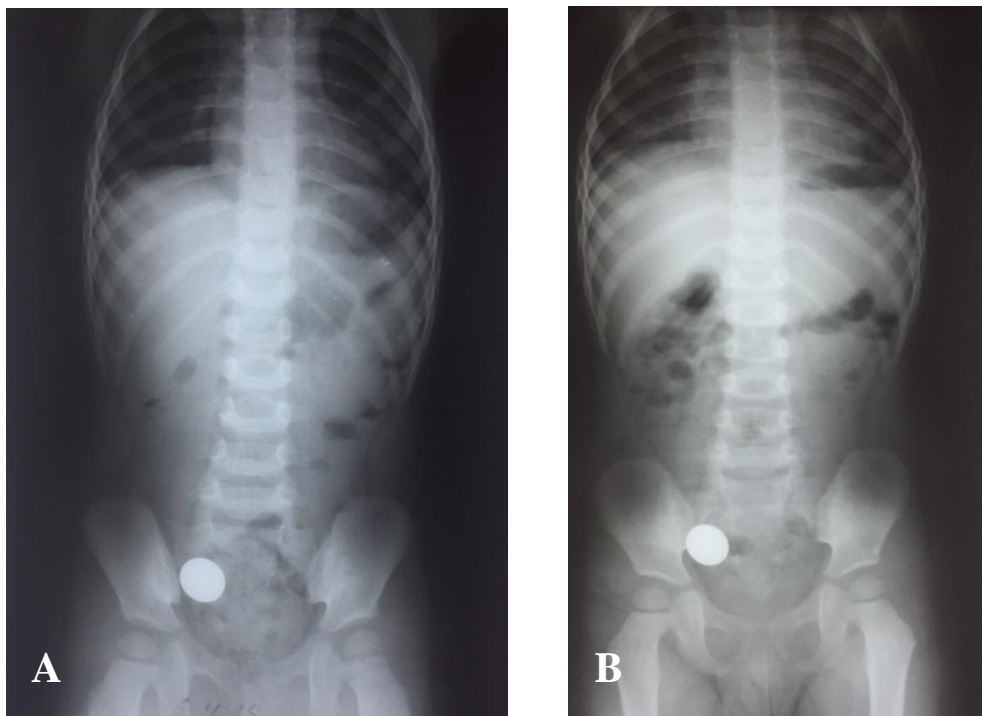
Survey X-ray of abdominal cavity of child H., 2 years 10 months of age on admission to hospital (A), a day after (B): on the right of the iliac region a foreign body (a coin) is determined
